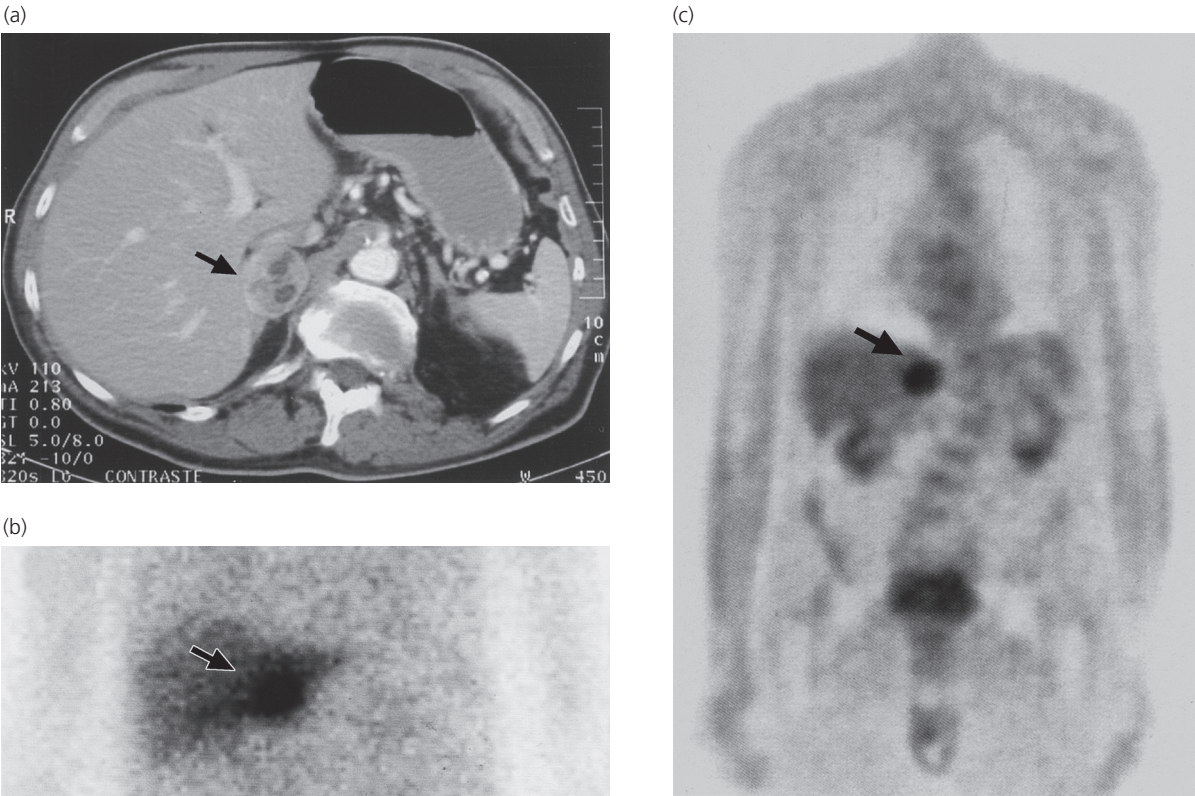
Pheochromocytoma in a 75-year-old man with recent-onset type 2 diabetes treated with a sulfonylurea, who was admitted on an emergency basis with severe chest pain and hypertension (blood pressure 240/130 mmHg). Blood glucose on admission was 27 mmol/L. Urinary catecholamine excretion was greatly increased, and a pheochromocytoma of the right adrenal was demonstrated by: (a) computed tomography; (b) scanning with ¹³¹I-metaiodobenzylguanidine, which is taken up by catecholamine-synthesizing tissues; and (c) positron emission tomography with ¹⁸F-fluorodeoxyglucose. After laparoscopic removal of the tumor, diabetes and hypertension both resolved.
